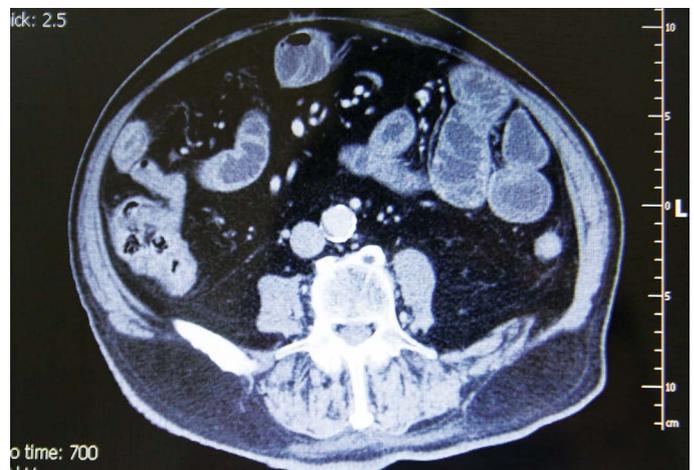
An abdominal CT image showing the cecum with thickened walls and the collapsed colon.
